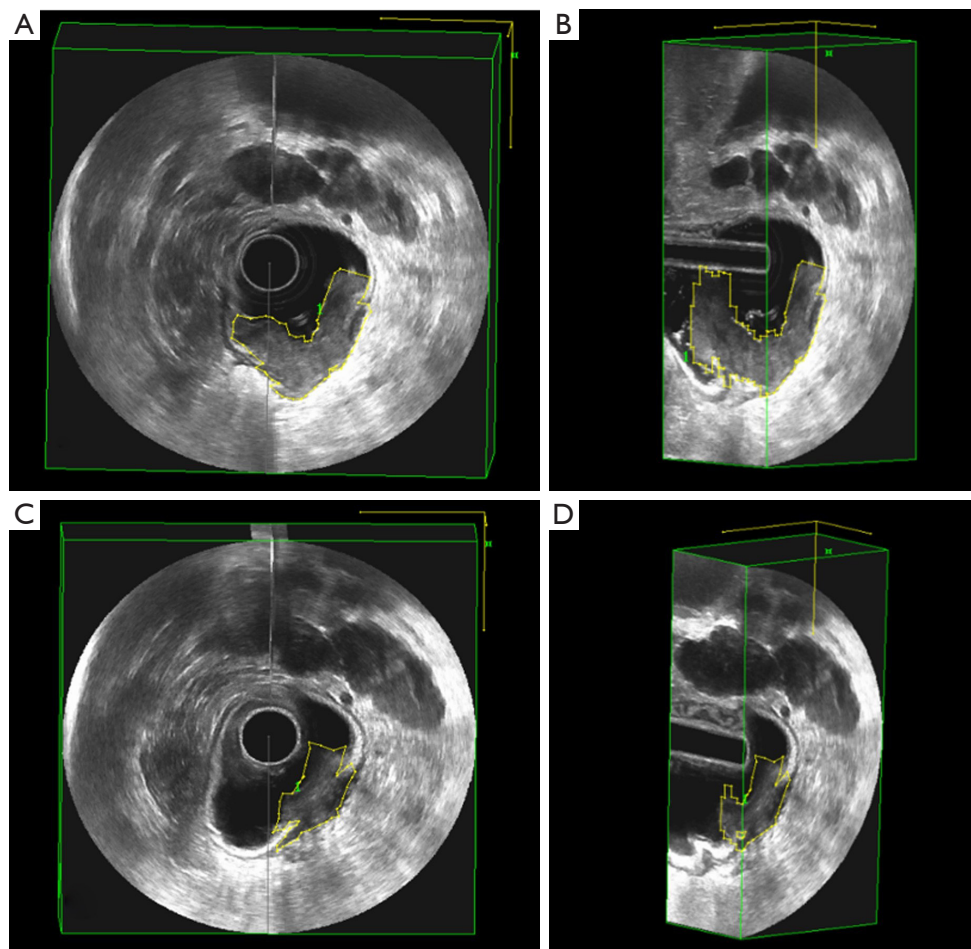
3D region-of-interest ERUS volumetry images measured on a 58-year-old man. (A,B) Tumor area manually traced on the 3D-ERUS before CRT. The pretreatment volume was 13.01 cm³. (A) Transverse-sectional tumor area. (B) Sagittal-sectional tumor area. (C,D) Tumor area manually traced on the 3D-ERUS after CRT. The post-treatment volume was 4.21 cm³. (C) Transverse-sectional tumor area. (D) Sagittal-sectional tumor area. The TVRR of this patient was 67.64% and the pathological TRG grade was 2. ERUS, endorectal ultrasound; CRT, chemoradiation therapy; TVRR, tumor volume reduction rate; TRG, tumor regression grade.
